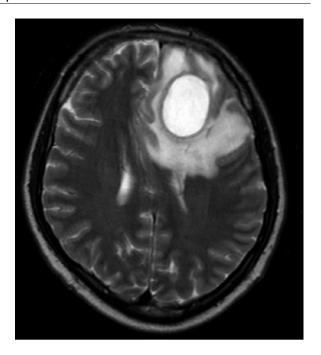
MRI of the brain indicating the collection of a large amount of fluid in the left frontal lobe and right-sided midline shift and a substantial mass effect on the left lateral and frontal lobe of the right lateral ventricle.
